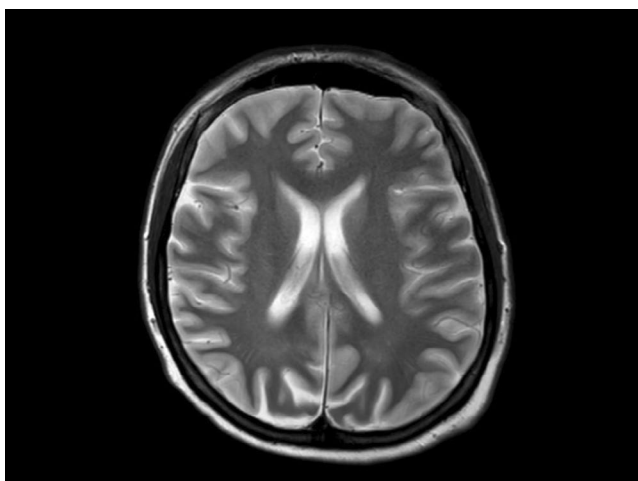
FLAIR hyperintensities in the bilateral cortical surfaces of frontoparietooccipital lobes
